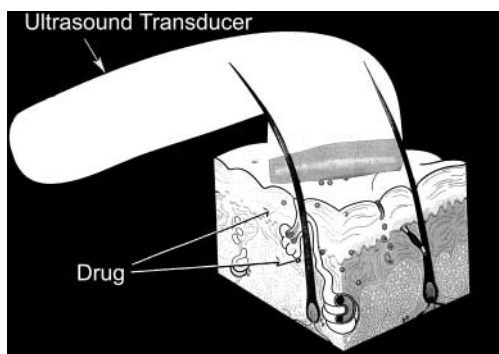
An ultrasound transducer is used to induce or deliver drug molecules (insulin) through the various layers of skin. (Reproduced with permission from ImaRx Therapeutics, Inc., Ref.^[77].)
